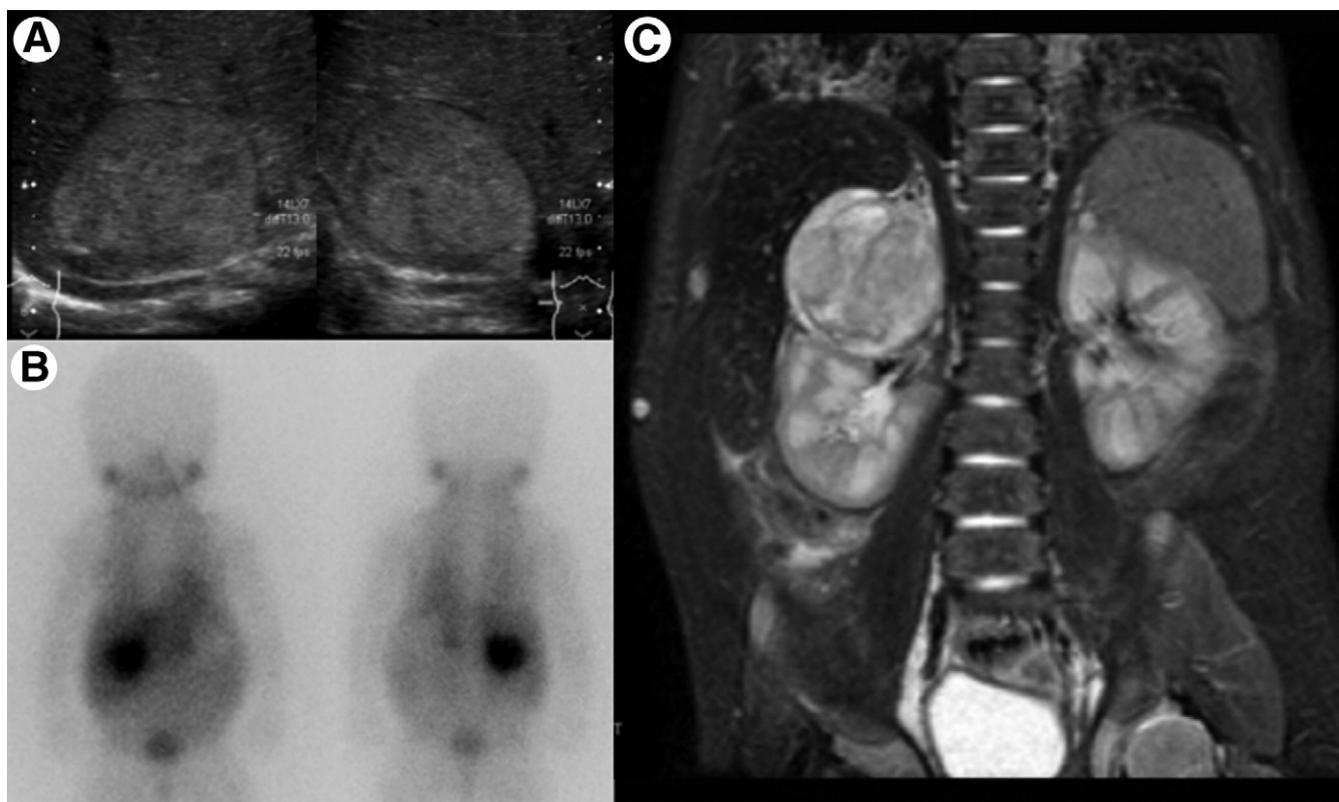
Neuroblastoma in a newborn. Postnatal ultrasound (A) confirms a solid mass in the right adrenal gland. ^{123}I -MIBG scan (B) confirmed avid uptake in the mass consistent with neuroblastoma. MRI (short-TI inversion-recovery) (C). The tumor was removed completely at surgery.
